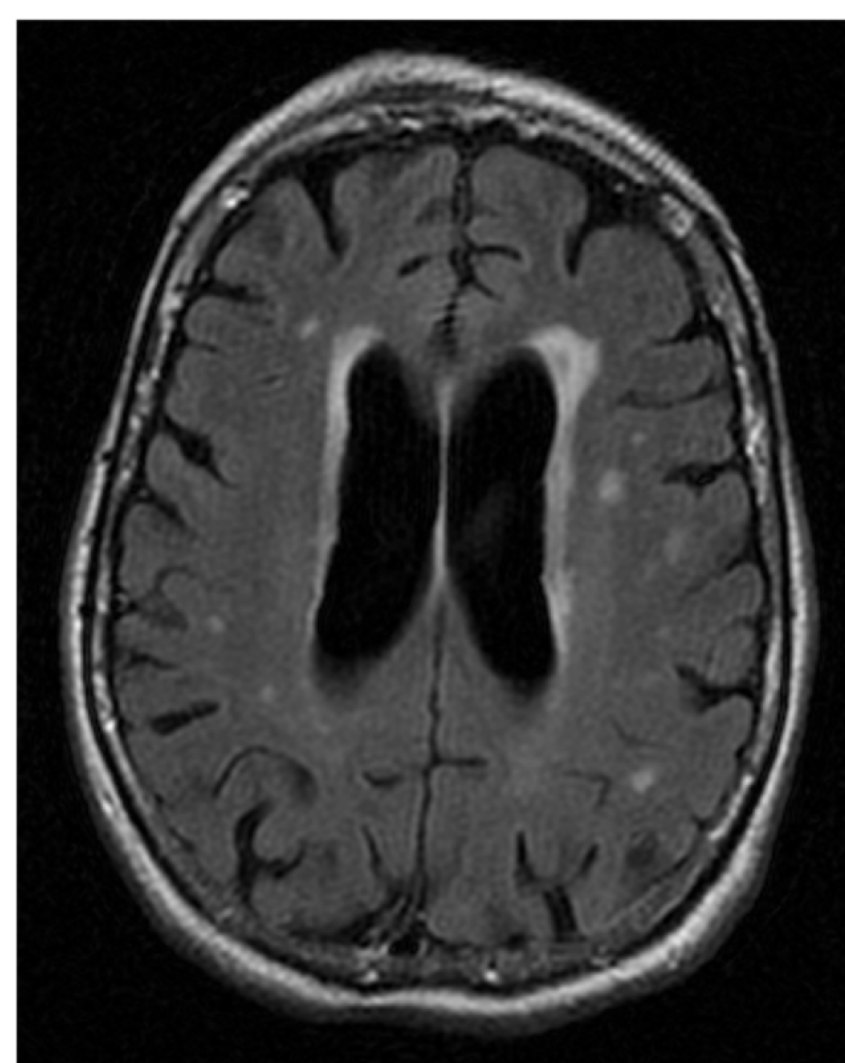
Axial FLAIR MRI showing a brain with low hyperintensity burden.
